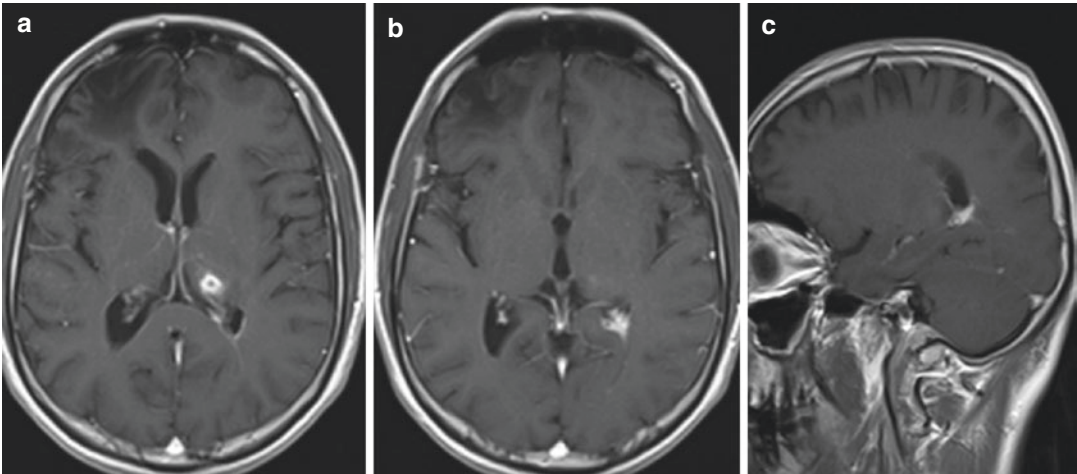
Axial (a, b) and sagittal (c) post-contrast T1-weighted MRIs demonstrate marked enhancement in posterior horn of *left* lateral ventricle and adjacent subtle
